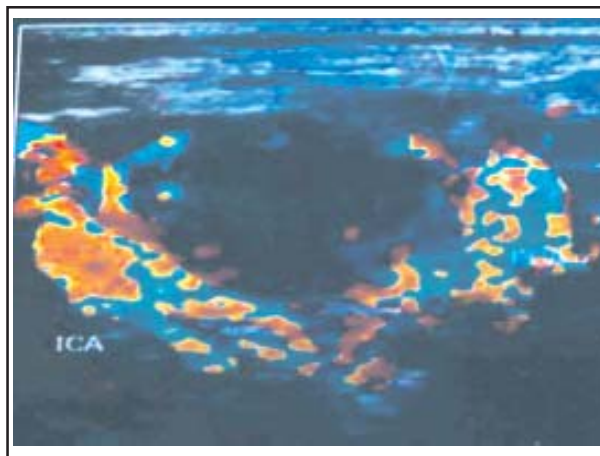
Carotid Color Doppler ultrasound image of one of our patients.
